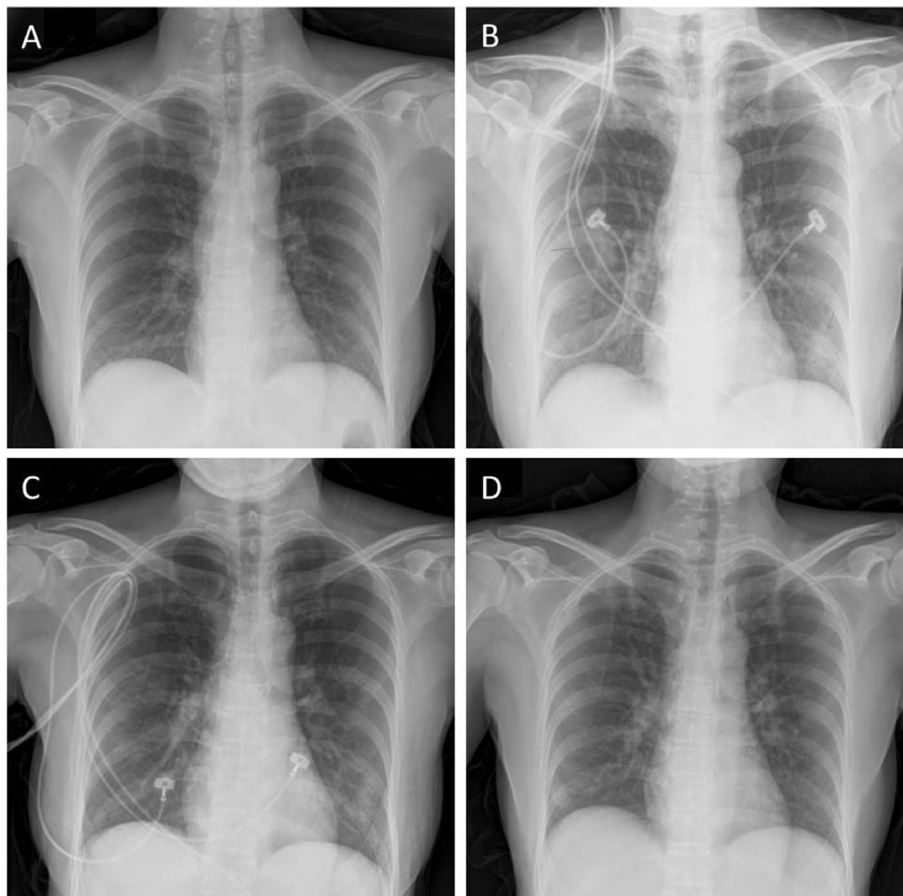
(A) Chest radiograph upon admission, (B) Chest radiograph on day 6, increased infiltrations at bilateral lung. (C) Chest radiograph on day 9, improvement of left lung infiltrations. (D) Chest radiograph on day 15, resolution of bilateral lung infiltrations.
